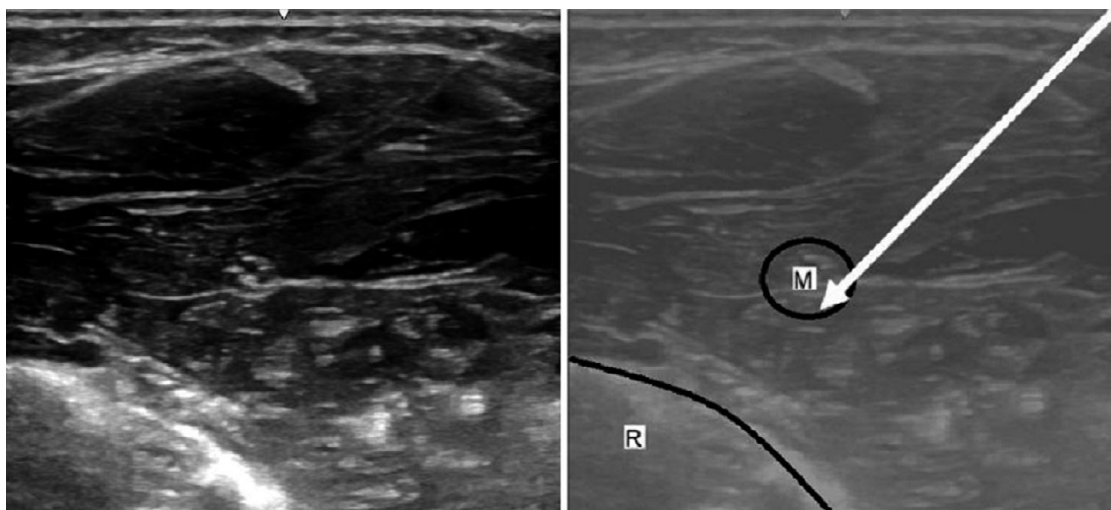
Ultrasound appearance of the median nerve (M) and radius bone (R) at mid-forearm.
